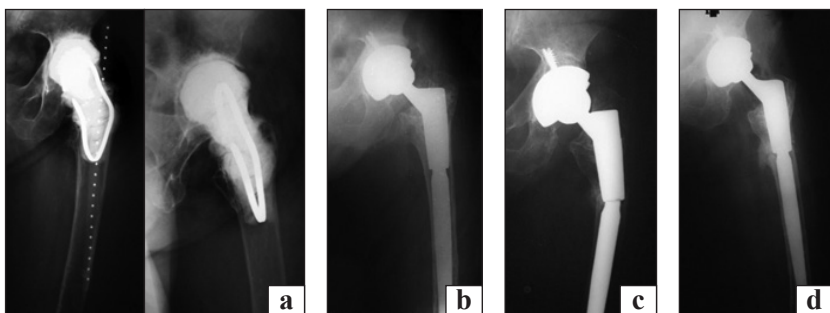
Patient K. Radiographs “before” and “after” surgical interventions: after revision of the left hip joint, removal of components and replacement of the defect with a metal-cement spacer (a); after revision arthroplasty (b); fracture of the modular stem of the endoprosthesis (c); after revision arthroplasty, osteotomy of the femur, removal of a stem fragment, replacement of the modular stem (d)
